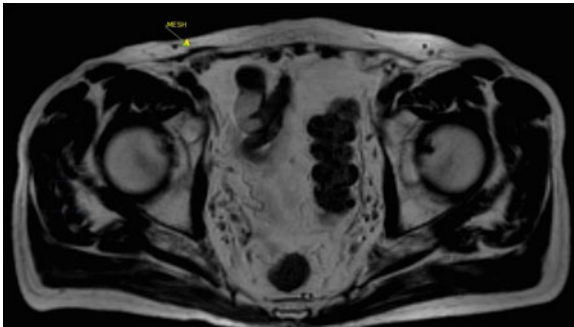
MRI anterior pelvis, non-contrast, with Valsalva and dynamic views demonstrated intact right inguinal hernia repair with no hernia recurrence. T2 axial view here shows intact flat onlay mesh (yellow arrow).
